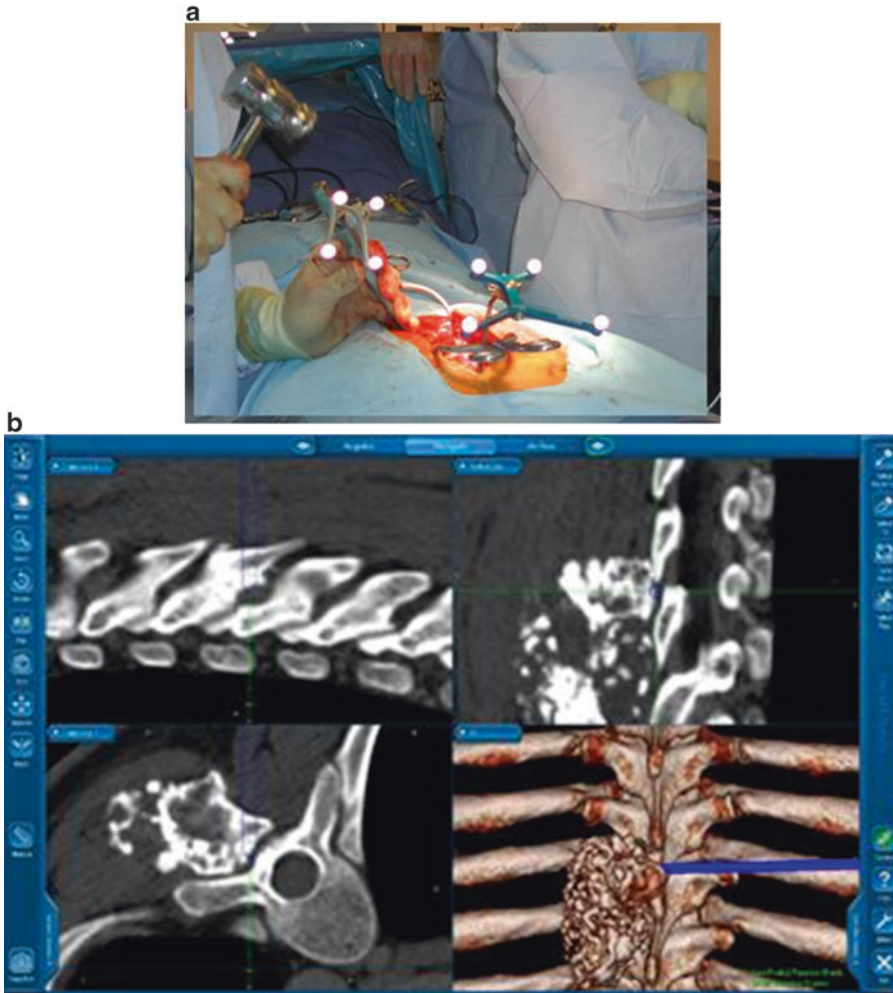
Case 2: (a) Intraoperative image demonstrating stereotactic osteotomies to deliver the tumor en bloc. (b) Medtronic Stealth (Memphis, TN) navigation was utilized to register the osteotomies to the preoperative CT images
